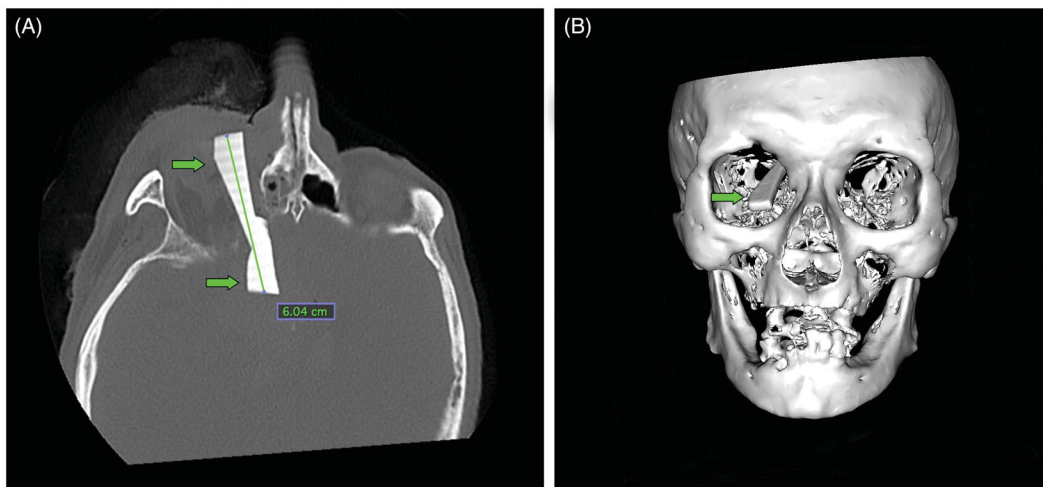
Preoperative CT scan. (A) 2D axial reconstruction of the 6.04 cm foreign body (green arrows) through the orbital roof. (B) 3D craniofacial reconstruction, anterior view; foreign body entering through the orbital roof (green arrow).
